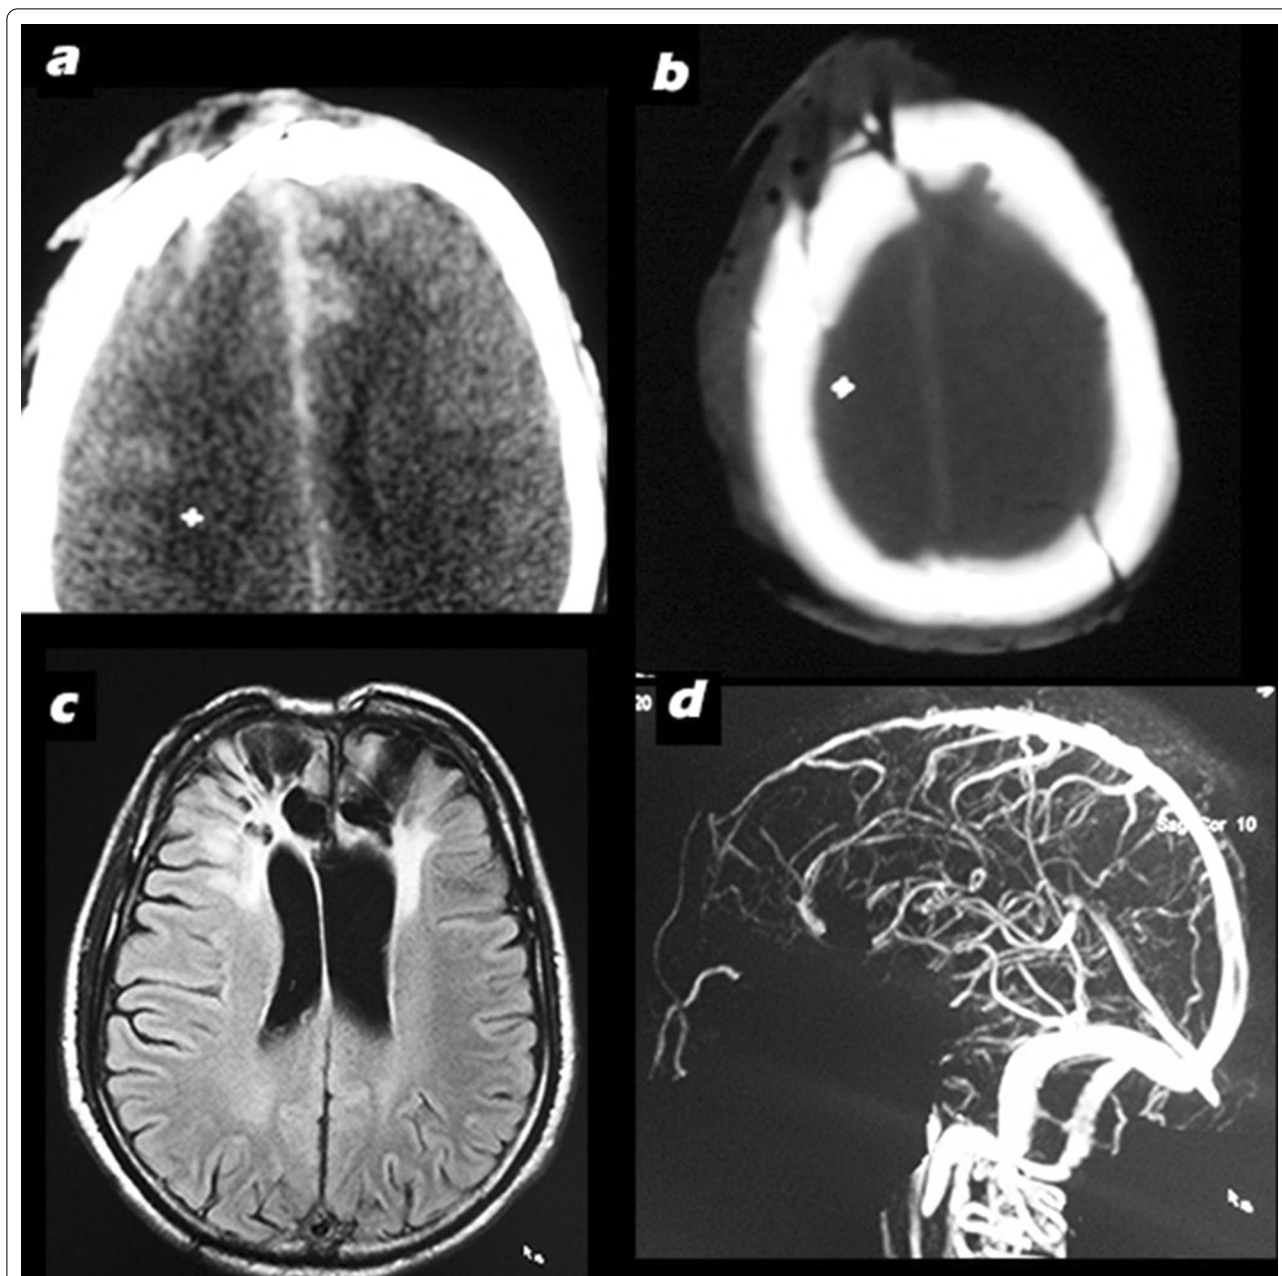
a CT brain showing comminuted depressed fractures with interhemispheric bleed and subarachnoid hemorrhage; b CT bone window showing depressed bone fracture segment in midline; c MRI brain showing bifrontal gliosis; d MR venogram showing narrowing of anterior third of superior sagittal sinus
